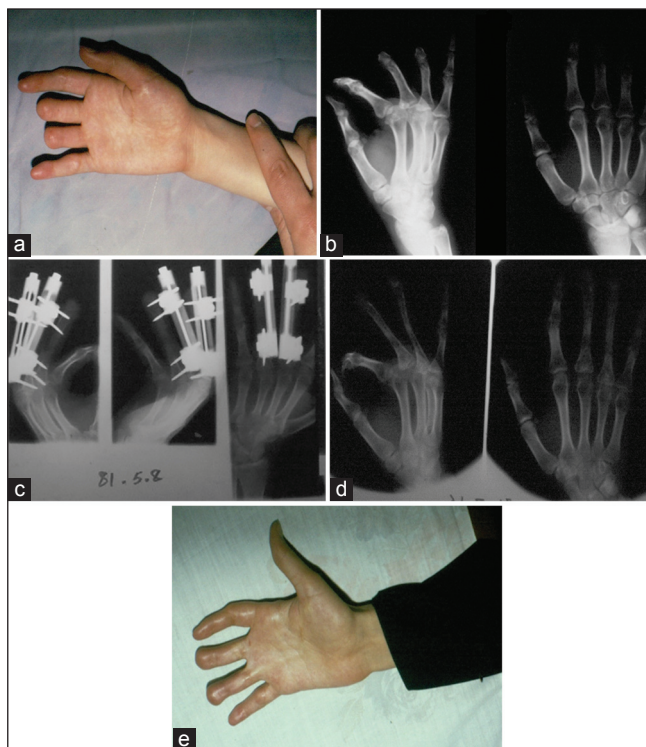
Distraction osteogenesis in patients with traumatic amputation of the fingers. Distraction was used for 3rd and 4th fingers bilaterally. (a) Preoperative photo of the right hand. (b) Preoperative radiograph. (c) Radiograph at the completion of the distraction. (d) Postoperative radiograph. (e) Postoperative photo of the right hand
